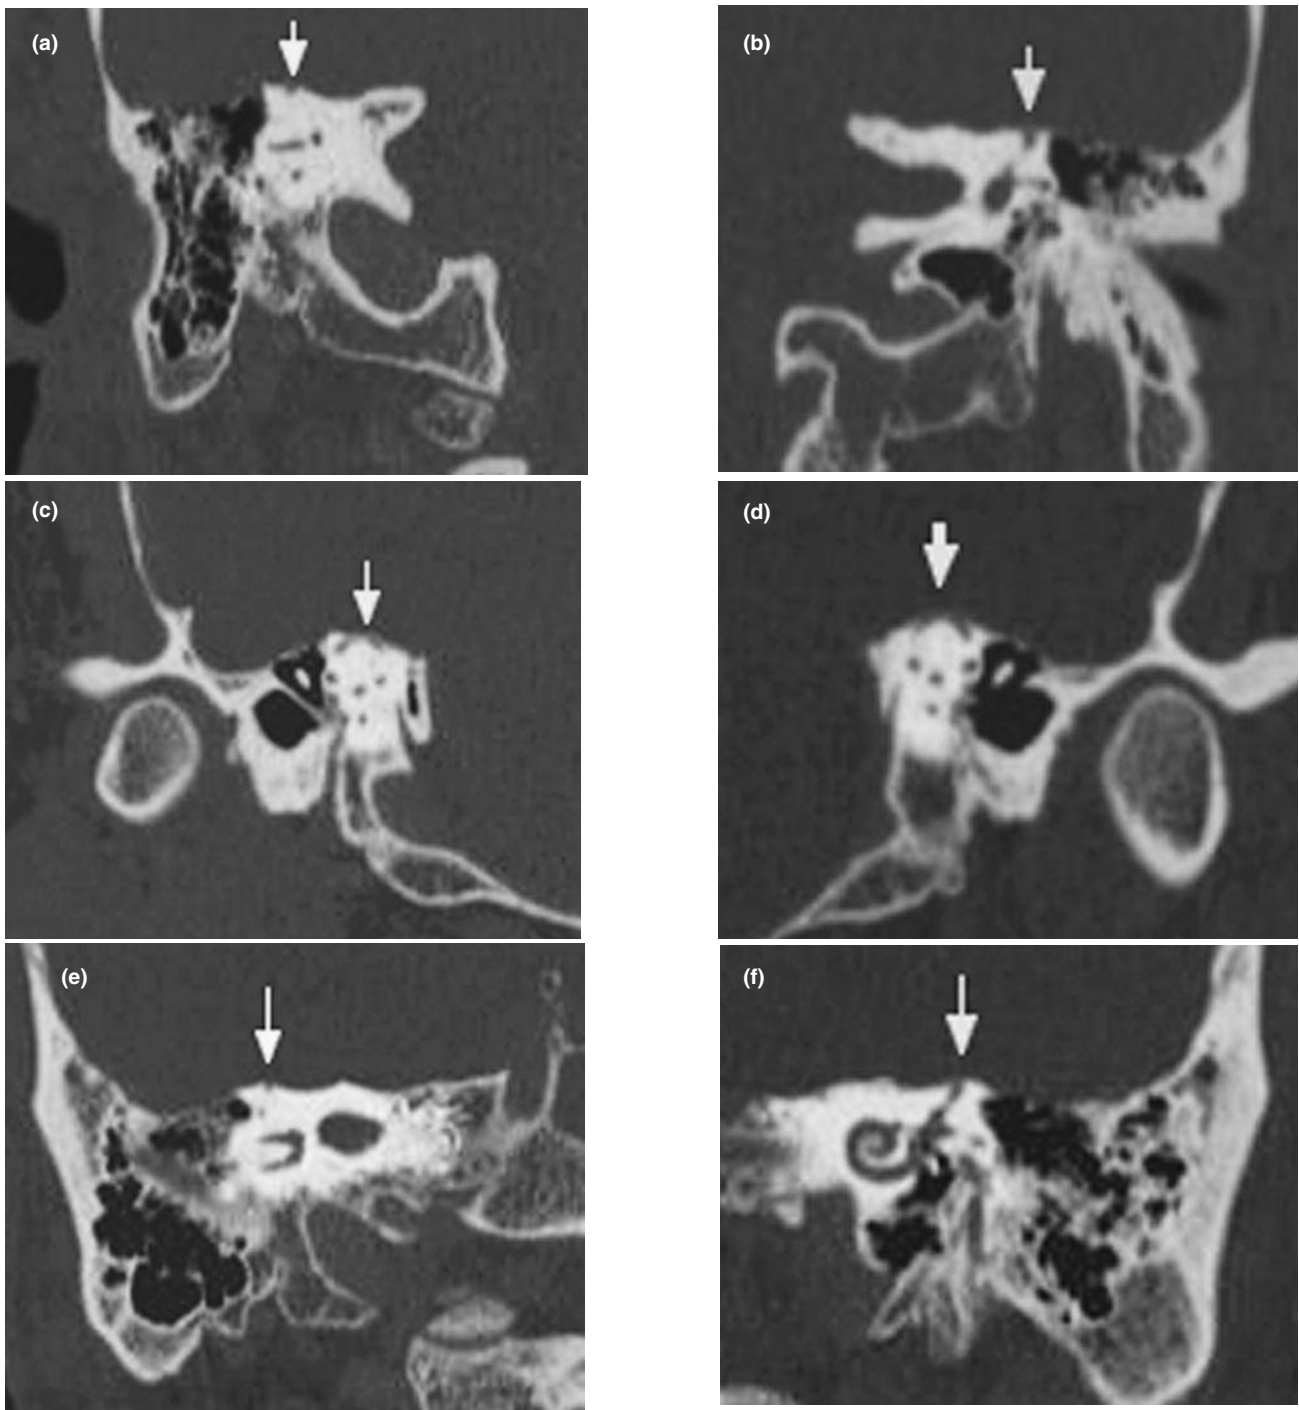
Male patient, 32 years old, complaining of vertigo (case 1 in table 1). CT temporal bone revealed: left sided SSCD which was seen in coronal images 5 mm interval (arrowed) (a), oblique sagittal plane (dehiscence measure was 5.2 mm) (arrowed), (b) and oblique coronal plane (arrowed) (c)
